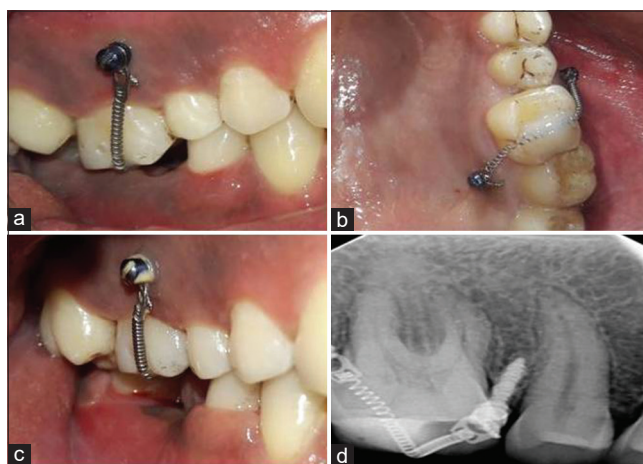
Miniscrew implant placement; (a) buccal view, (b) occlusal view, (c) post-6 months miniscrew implant placement, (d) intraoral periapical post-6 months miniscrew implant placement, suggesting no periapical pathology
